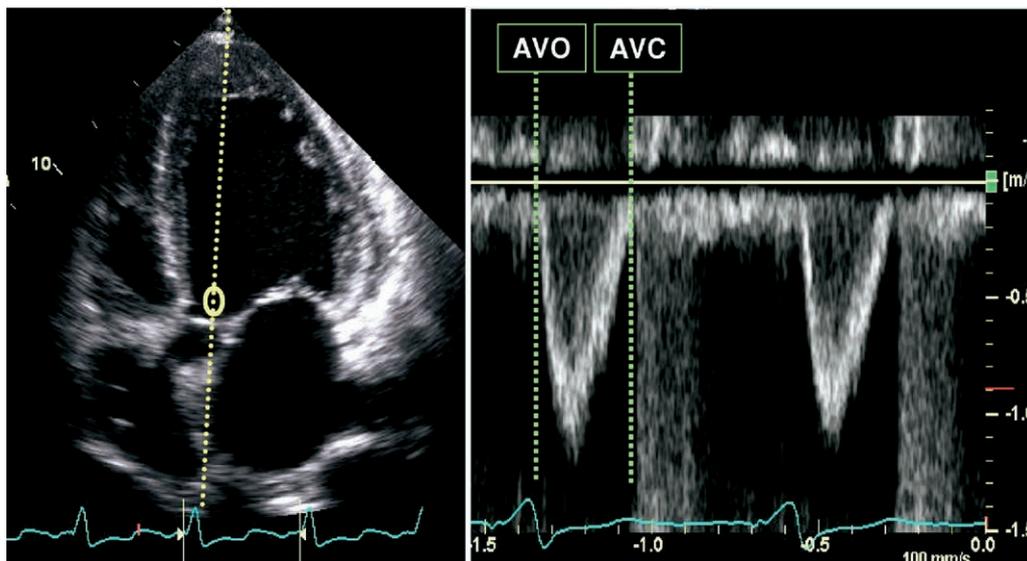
Determination of left ventricular ejection interval from pulsed Doppler of outflow tract. AVC, Aortic valve closure; AVO, aortic valve opening.
